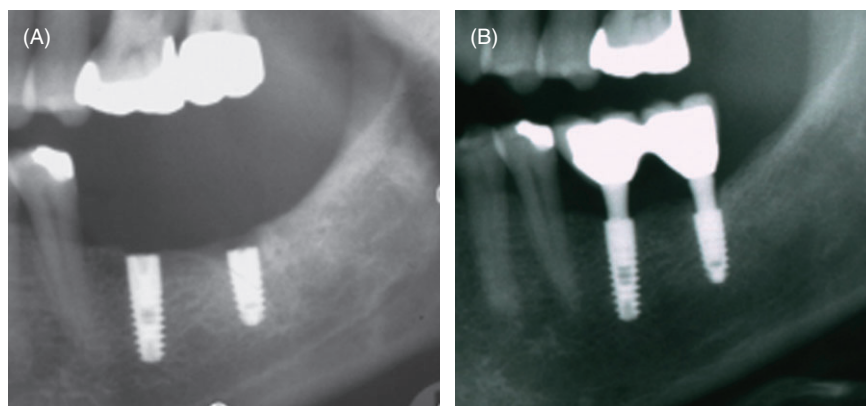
A, Radiographic evaluation after subcrestal placement of 2 implants (baseline). B, Radiographic evaluation after subcrestal placement of two implants (13 years follow-up) demonstrating no bone loss.
